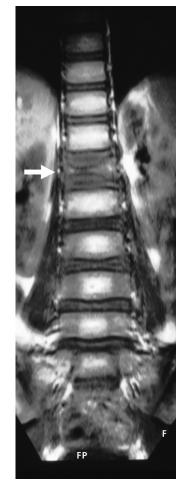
Magnetic resonance image depicting a vertebra plana secondary to involvement of the vertebral body with Langerhans cell histiocytosis (white arrow).
